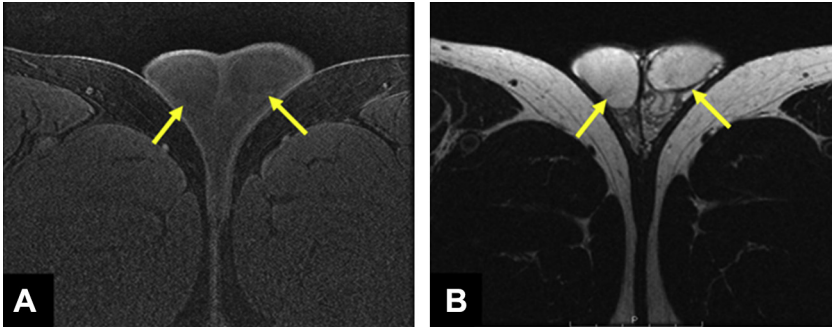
Normal testicles. (A) Axial T1-weighted image shows homogeneous intermediate signal intensity of bilateral testicles (*arrows*). (B) Axial T2-weighted image shows high signal intensity of both testicles (*arrows*).
